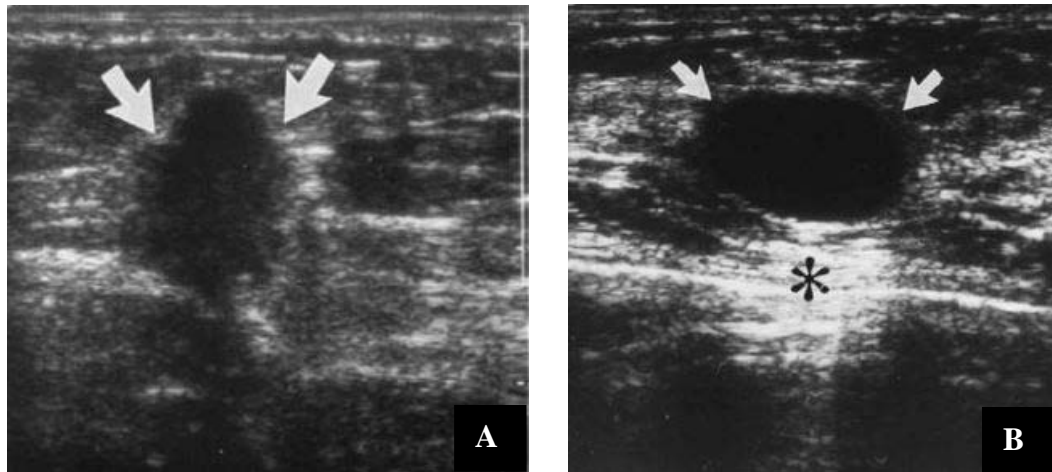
A: Ultrasonogram of a breast carcinoma, with arrows indicating ill-defined margins and low-level heterogeneous internal echoes
